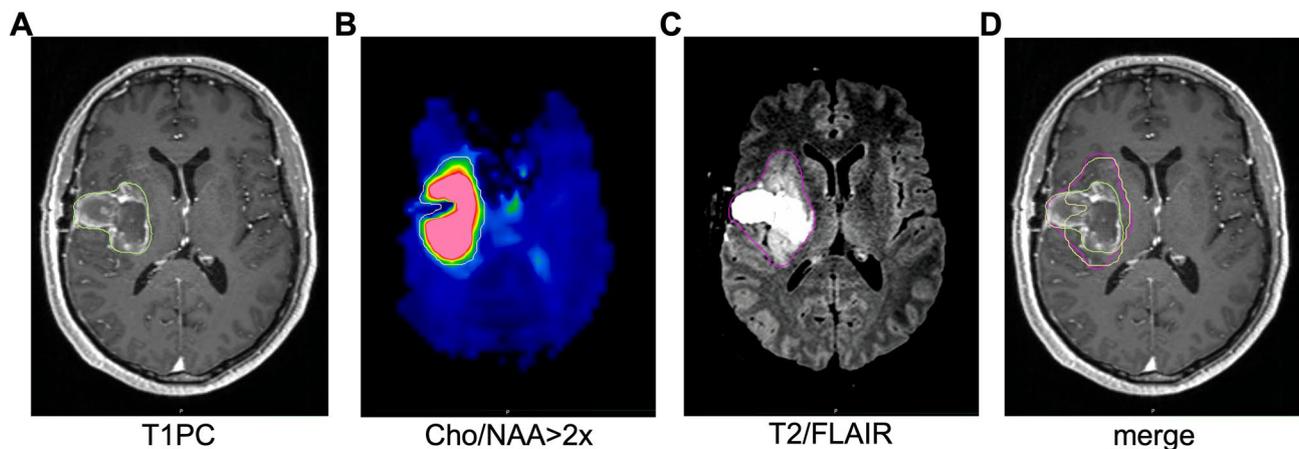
Example contours from a patient with primary GBM. A-D. Example contours for a patient with pGBM show T1PC, Cho/NAA > 2x, and T2/FLAIR volumes. Merge image shows extension of Cho/NAA > 2x outside of the T1PC-defined volume but mostly within the T2/FLAIR volume
